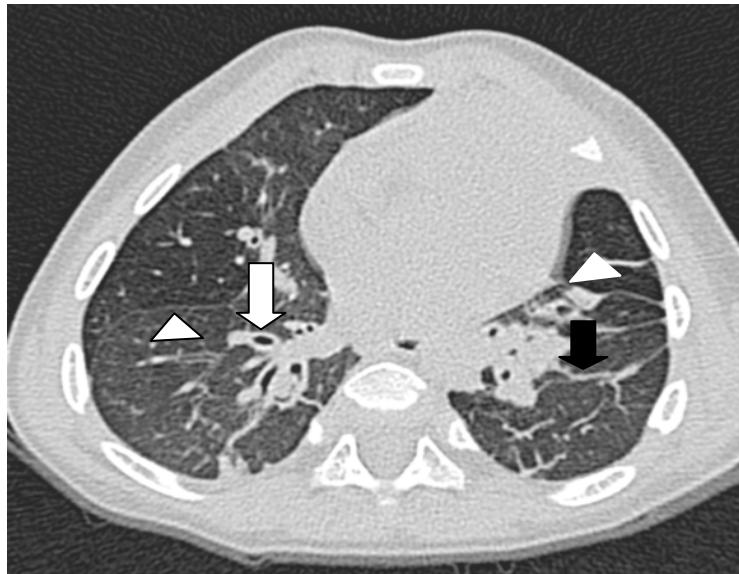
13 months-old boy with severe BPD. Inspiratory axial CT showing regions of attenuation (arrowheads), parenchymal linear opacities (black arrow), bronchial wall thickening and bronchiectasis (white arrow).
